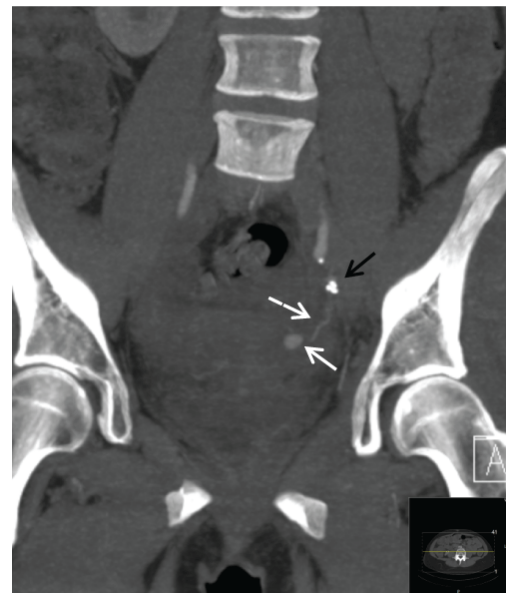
Computed tomography (coronal) of the lower abdomen demonstrating collateral filling (dotted arrow) of the pseudoaneurysm (straight white arrow) despite coiling at the origin of the uterine artery (black arrow).
